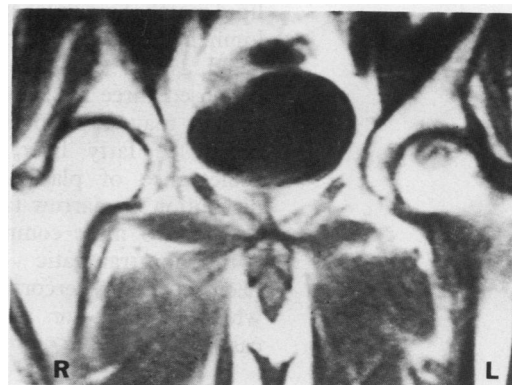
A magnetic resonance imaging scan showing the decreased signal in the T1 weighted image in the necrotic region of the left femoral head.
